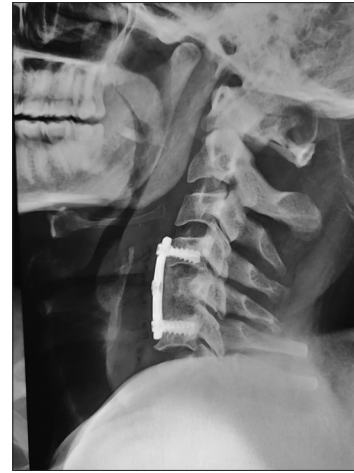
Postoperative plain lateral radiograph demonstrating C5 corpectomy, bone grafting, and anterior cervical plating
